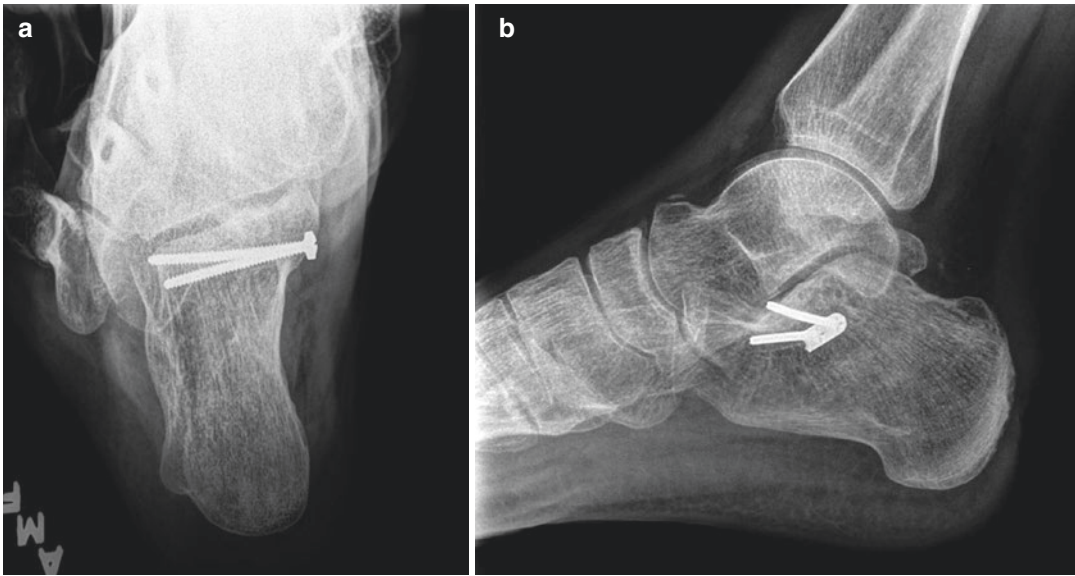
(a, b) Follow-up for Case 2. “Two-year follow-up radiographs demonstrate preservation of the subtalar joint space on the Harris heel view (a) and talar dome lateral (b)”
